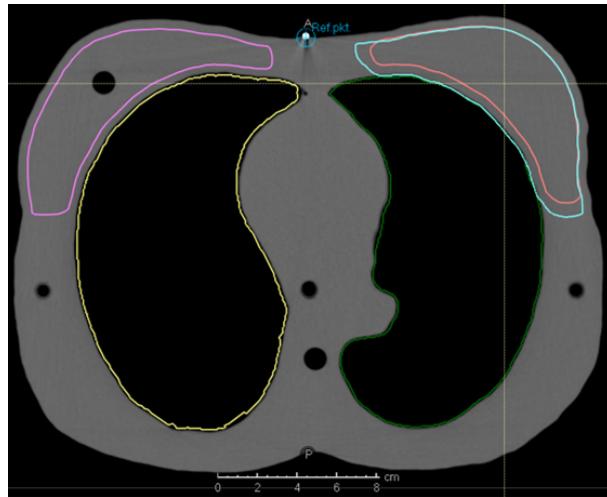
A CT image including the delineation of important regions of interest when irradiating a breast. Target volumes: the CTV of the left breast (pink), the PTV of the left breast (blue), and organs at risk: the left lung (green), the right lung (yellow) and the contralateral breast (purple).
